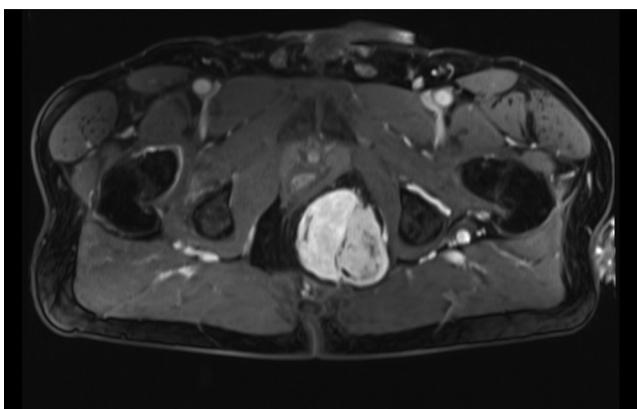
T1-MRI-Scan: the tumour is hypervascularized in the Fossa ischioanalisis.
